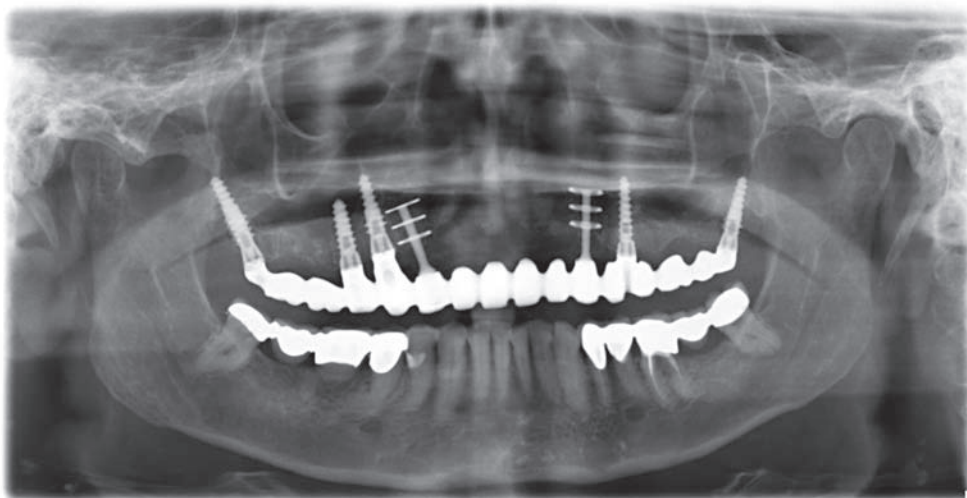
Postoperative radiograph showing the basal and crestal implants, splinted by an immediately loaded fixed bridge. Basal and crestal implants were chosen based on the available vertical and horizontal bone and the situation at the extraction sites.
